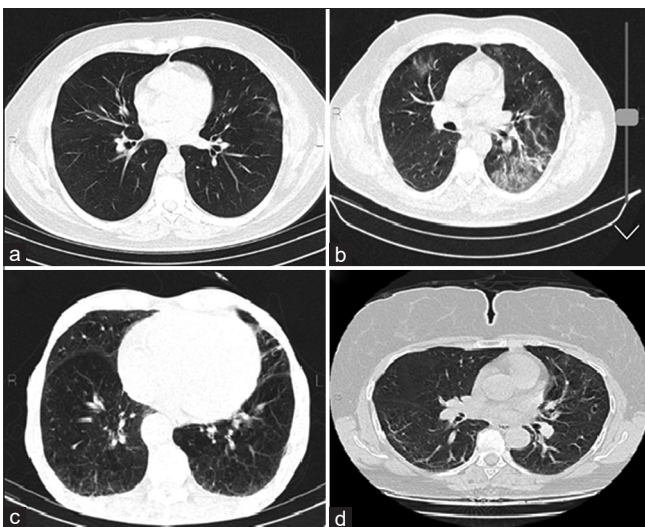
Abnormal computed tomography scan patterns in coronavirus 2019 patients at 3, 6, and 12-month follow-ups. (a) Ground-glass opacity, (b) Irregular lines, (c) Reticular pattern, (d) Subpleural line
